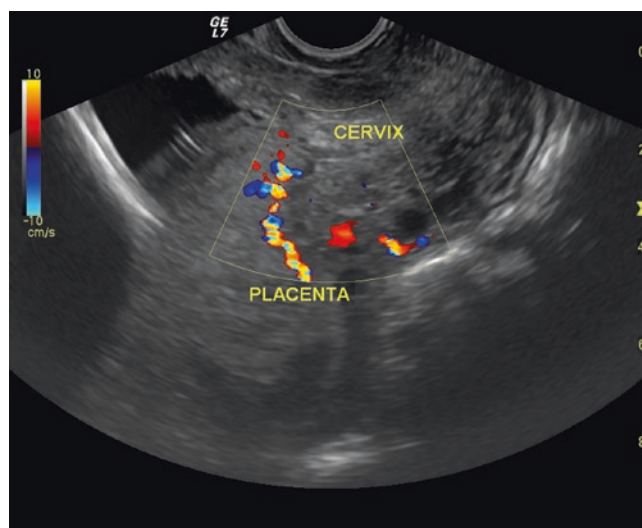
A transvaginal ultrasonographic scan of lateral placenta previa
